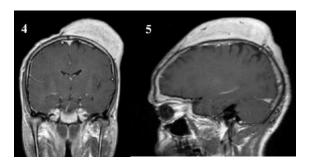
MRI with contrast: Show diffuse enhancing purely extra cranial mass along the left parietal convexity. Intracranial structures are normal.
